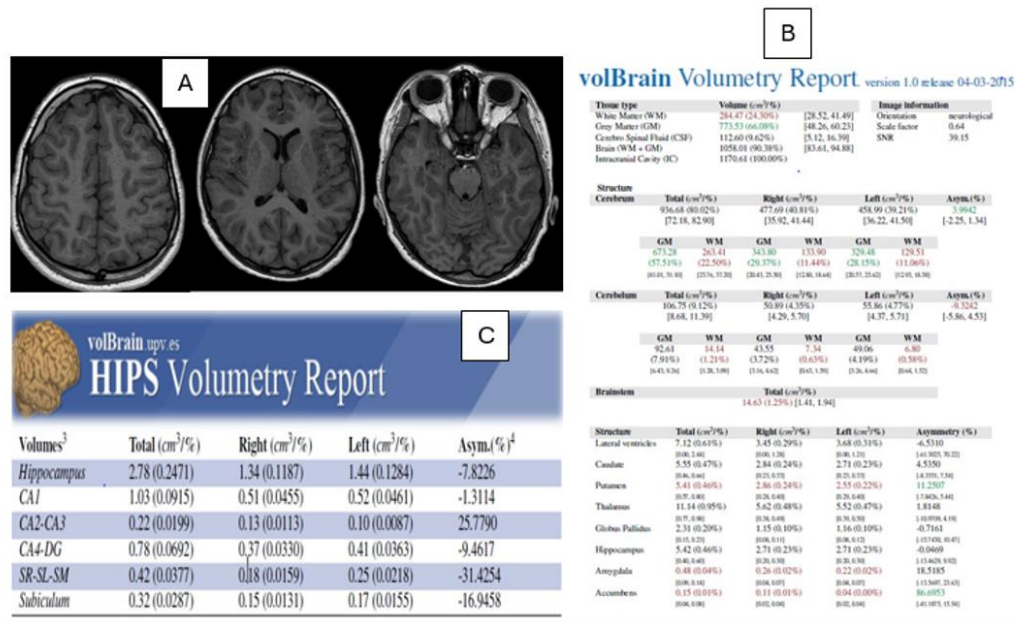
A 9-year-old male patient with generalized tonic-clonic seizures. A. The 3D axial MRI of the brain shows no structural abnormalities or abnormal signals. B. MRI volumetry indicates an increase in the volume of grey matter, while showing a reduction of white matter, putamen, amygdala, and accumbens volumes. There is also asymmetry between the right and left putamen and accumbens. C. The MRI volumetry shows normal volume for the hippocampus and its segments
